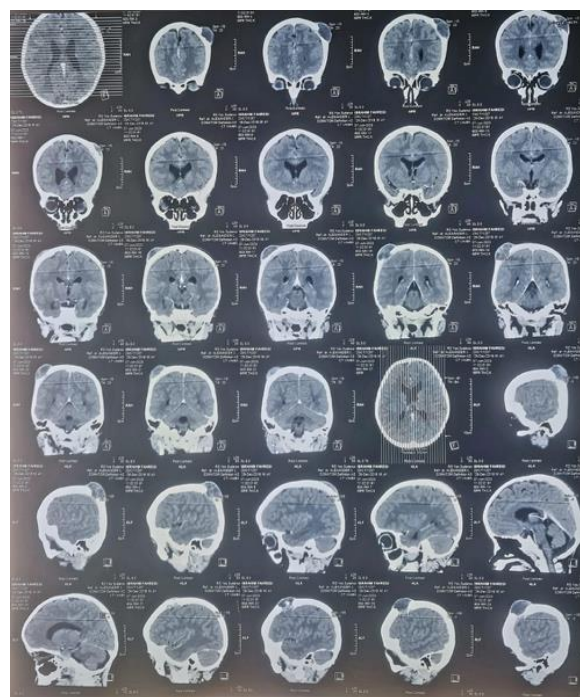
HEAD CT SCAN WITH CONTRAST SHOWED MULTIPLE SOL, RIGHT AND LEFT OS PARIETAL BONE DESTRUCTION
